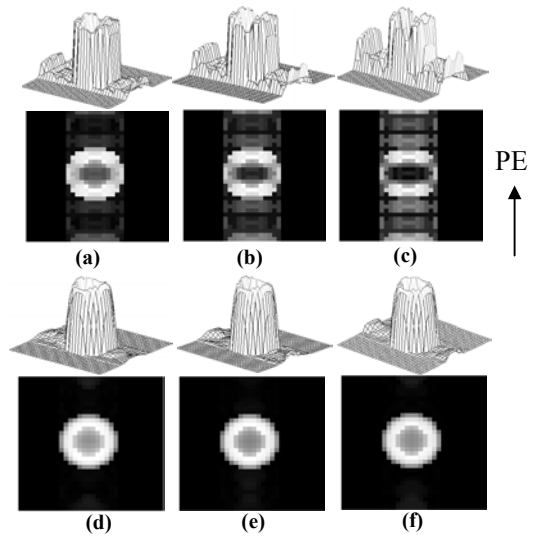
(a-c): DWI-PGSE; (d-f): DWI-DDF. The motion frequency is 1.25 Hz and the motion amplitudes of the sample are 1.9 mm (a,d), 2.0 mm (b,e), and 2.2 mm (d,f), respectively.
